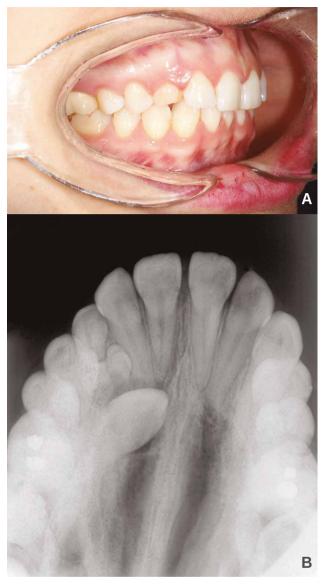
clinical case 2; a, lateral intra-oral photography shows tooth 53 that has not been exfoliated; b, occlusal radiography reveals the presence of a supernumerary odontoma or a tooth that is probably responsible for the inclusion of 13.
